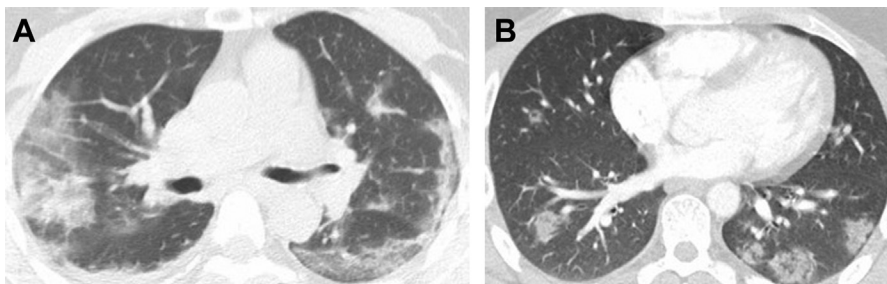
Two axial CT images of the chest demonstrate basilar and peripheral predominant mixed ground glass and consolidative opacities in a distribution typical for SARS-CoV-2 viral pneumonia.
